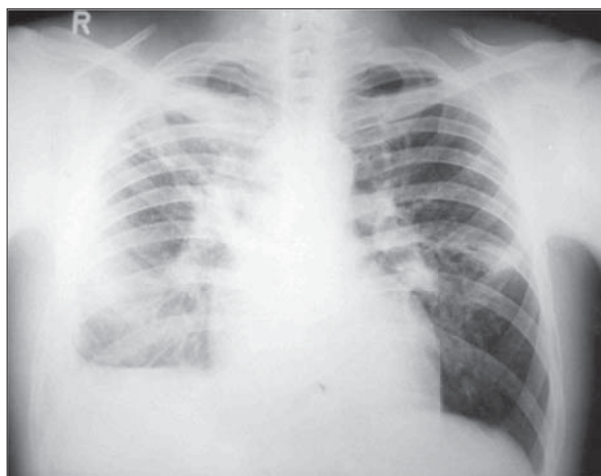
Chest radiography seven days after admission; under diuretic (and antibiotic) treatment, left-sided pleural effusion disappeared (clearly shaped left diaphragm and costophrenic sinus) together with majority of pulmonary shadows that belonged to hydrostatic pulmonary oedema
